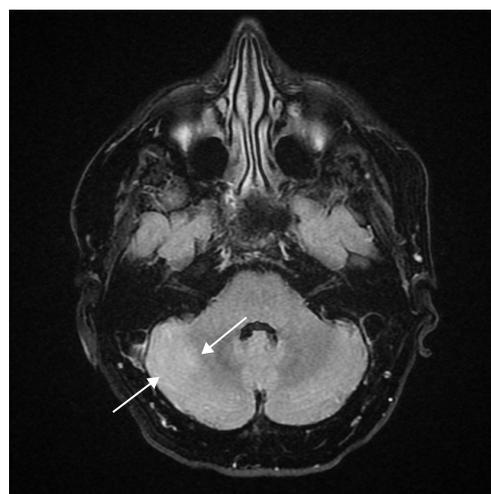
Magnetic resonance imaging in a 41-year-old patient, showing increased signal in the right cerebellar hemisphere (arrows) on a fluid-attenuated inversion recovery image
